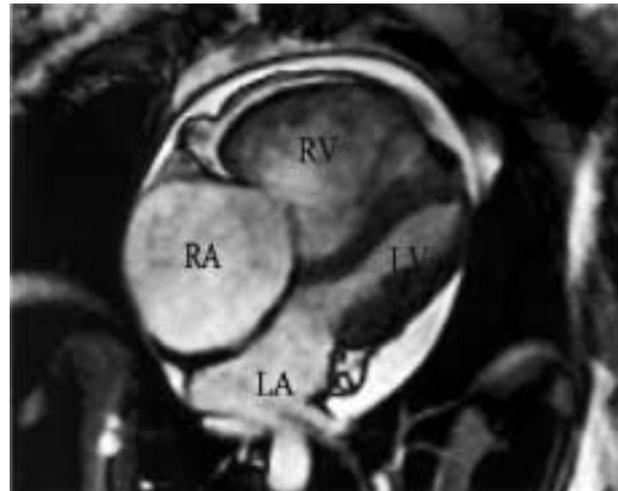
Cardiac MRI image revealing grossly dilated right heart chambers in a patient with primary pulmonary hypertension. LV = Left ventricle, LA = Left atrium, RV = Right Ventricle, RA = Right atrium.
